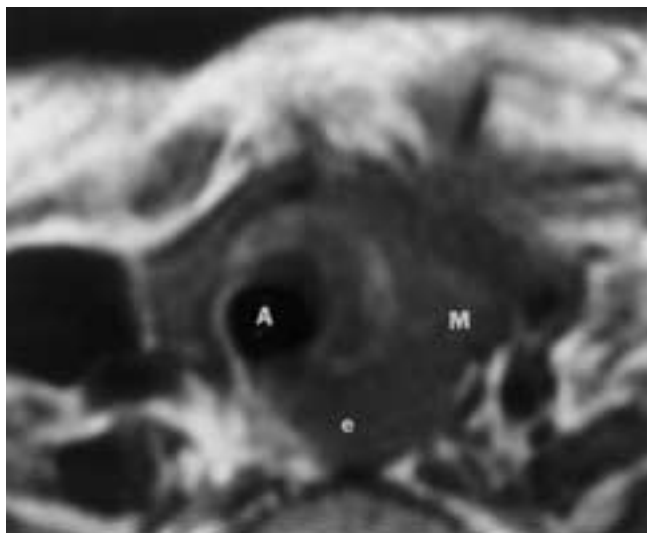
Parathyroid carcinoma invading the airway. Unenhanced axial T1-weighted MR image shows a poorly defined soft-tissue mass (*M*) just below the inferior pole of the left lobe of the thyroid gland. The fat plane between this mass and the esophagus (*e*) is obliterated, and there is extension into the left lateral wall of the adjacent airway (*A*).
